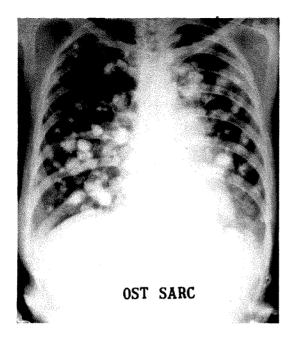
Roentgenogram showing calcium production of lung metastases. Patient lived nine years following removal of primary osteogenic sarcoma. Steady increase in calcium formed in metastases over period•of several years.
